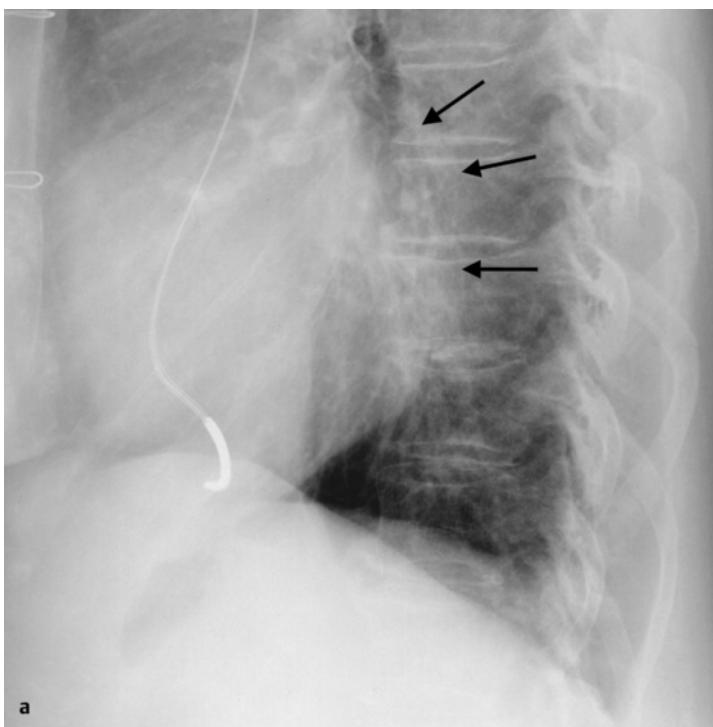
a,b Enlarged left atrium protruding into the posterosuperior cardio-mediastinal shadow. Generalized enlargement of the heart, particularly pronounced at the level of the left atrium (black arrows) and right ventricle (after placement of three prosthetic valves). CT (b) demonstrates the posterosuperior protrusion.
